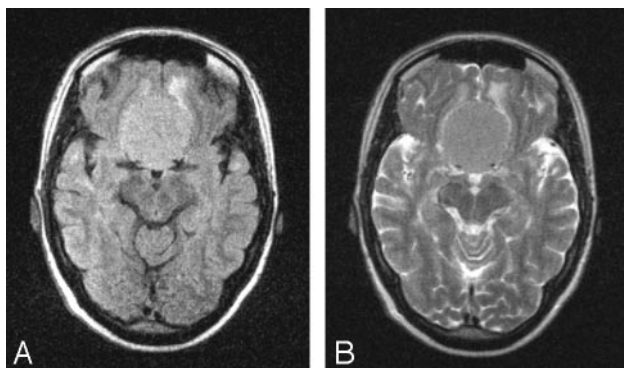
Meningothelial meningioma (A) FLAIR image (relative intensity of tumor, 1.11). B, T2-weighted image (relative intensity, 1.05). Surgical bleeding, grade 8 on VAS and blood loss during surgery, 700 mL; hardness 4 on VAS; collagen content, 1; progesterone receptor expression, 3; microvessel density, 151 microvessels/mm². Time to maximum enhancement in dynamic imaging was 22 seconds from the time point when contrast agent arrived in the veins.
